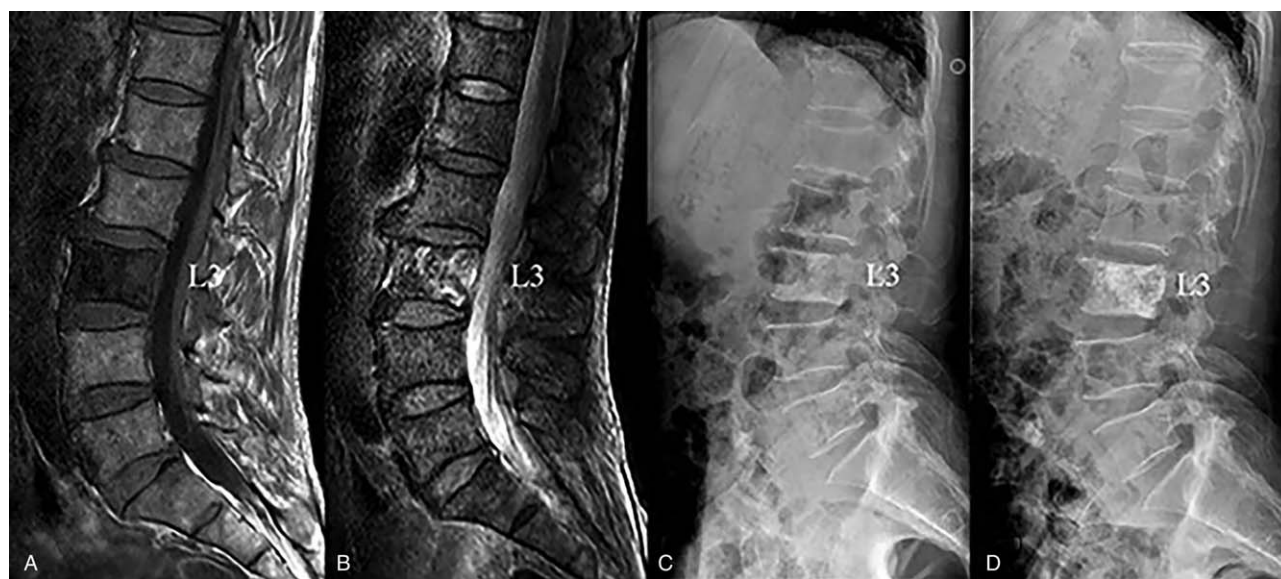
A representative case of a male patient with L3 OMVT who received KP treatment. (A and B) Preoperative MRI examination. There were MRI signal changes in the T1wi and T2wi. Low signals on the T1 sequence and high signals on the T2. (C and D) A comparison of preoperative and postoperative X-ray. No bone destruction and vertebral collapse were observed in preoperative X-ray.
